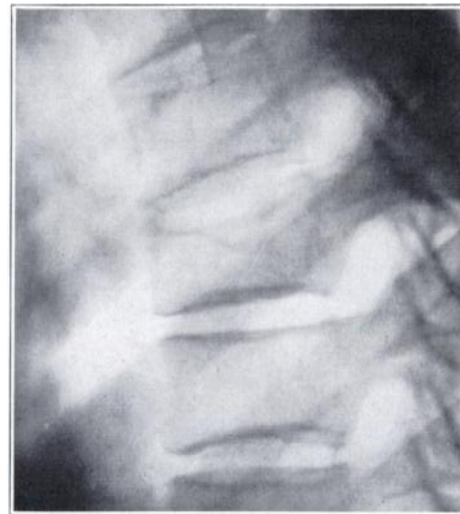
X-ray of epileptic, Case No. 101. Major fracture—D7.
